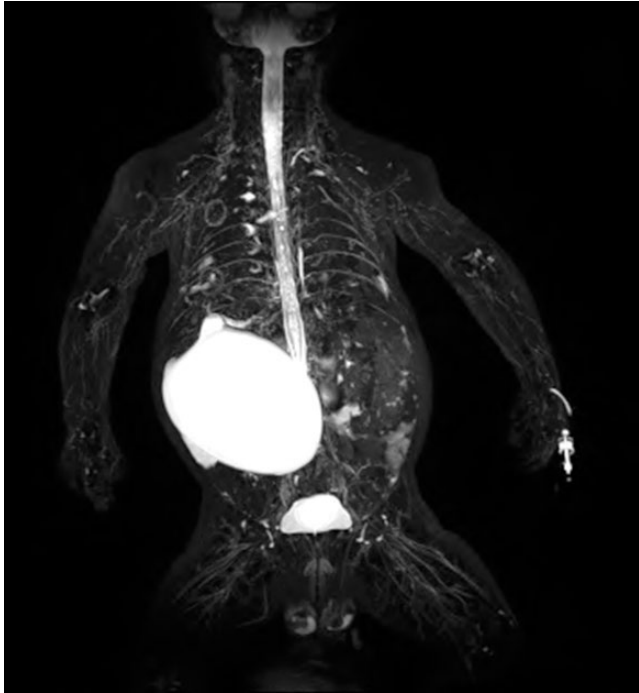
Antenatally diagnosed type 1C choledochal malformation. MRI scan reconstruction showing huge cyst extending from the liver to the pelvis. Intraoperative pressure measured at 25 mmHg with bile amylase of 10 IU/L. (Reproduced courtesy of Mr Brice Antao, Department of Pediatric Surgery, Crumlin Hospital, Dublin, Ireland.)
